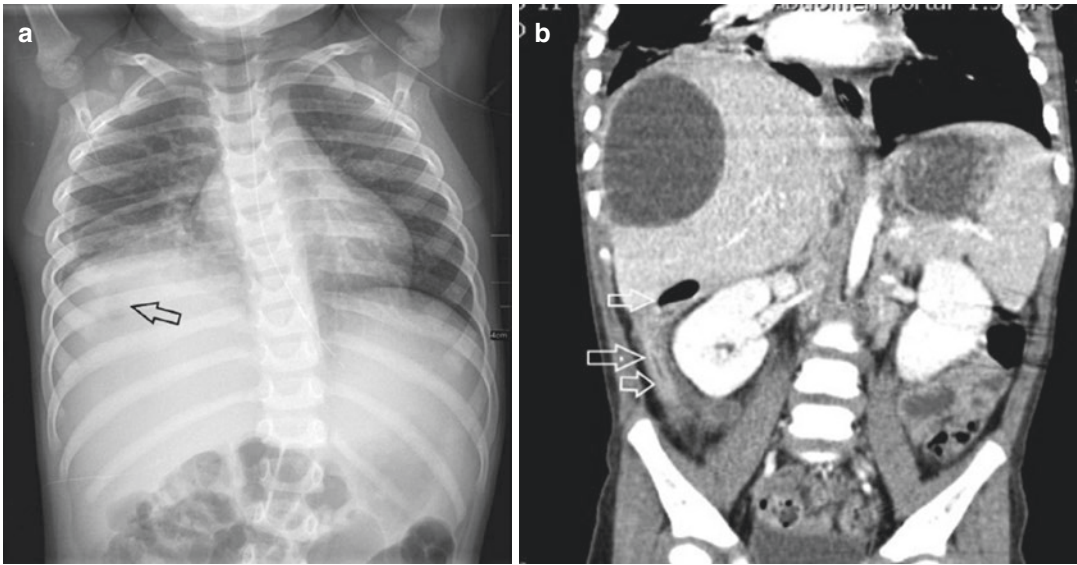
Sub-diaphragmatic abscess masquerading as right pleuro-pneumopathy in a 2-year-old boy. (a) Chest radiograph demonstrates hypoventilation and pleural effusion of the right basis. A small air bubble is superimposed to the liver. (b) CE-CT—Reformatted frontal view (US
